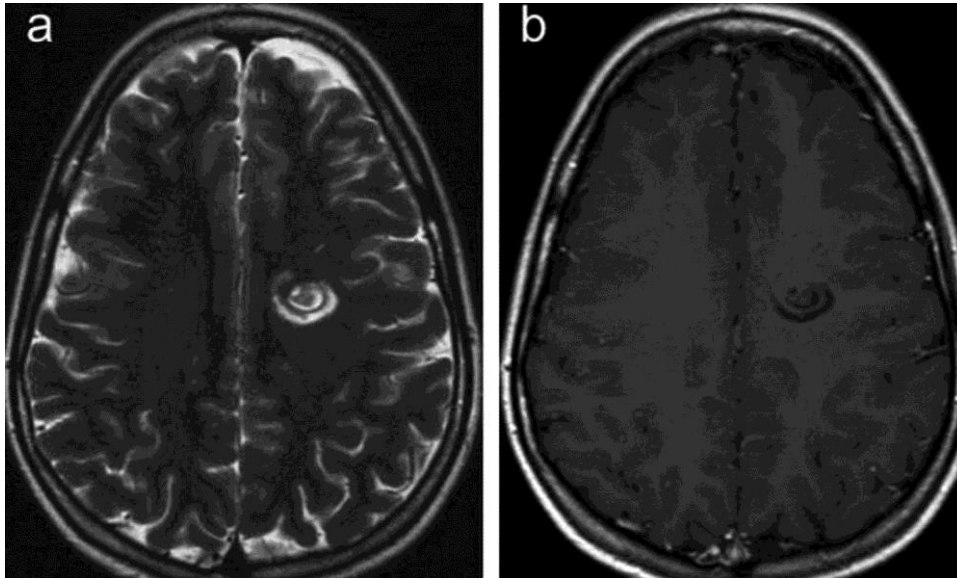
a Axial T2W MRI (follow-up MRI at 4 months) shows very well delineated concentric rings within the Balo lesion. No peri-lesional oedema is seen. b Corresponding contrast-enhanced axial T1W MRI shows interval regression of the previously noted contrast enhancement within the lesion.
